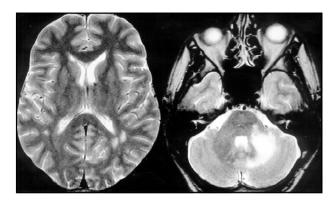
Cranial MRI (T2 weighted) showing hyperintense lesions in the white matter near the left occipital horn (a), cerebellum and left middle cerebelar peduncle (b).
